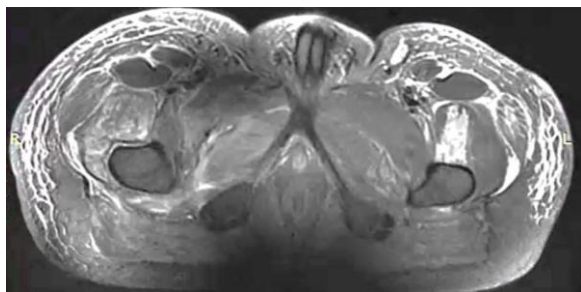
Magnetic Resonance Imaging of bilateral thighs showing T2/STIR hyperintense areas involving bilateral quadriceps, muscles of the right adductor compartment (right more than left), and bilateral gluteus medius muscles
